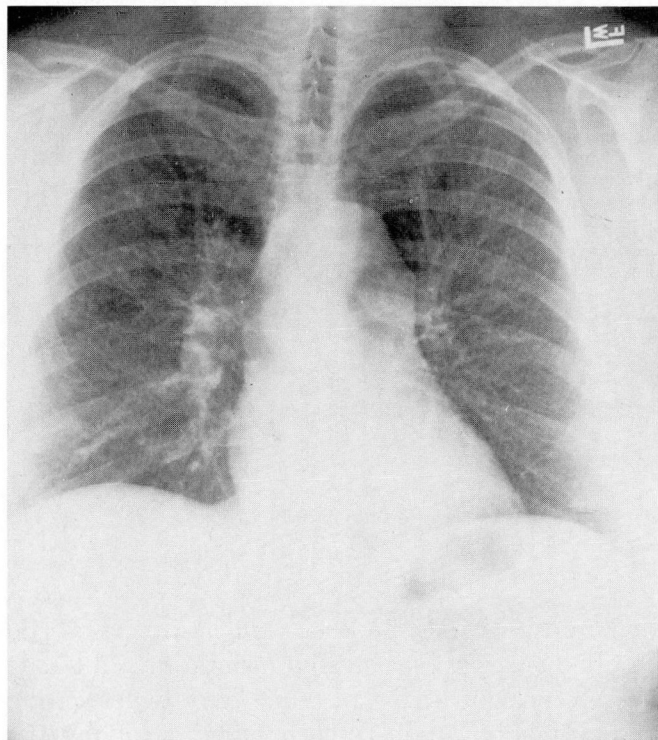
Posteroanterior chest radiograph showing mild pulmonary artery prominence.
